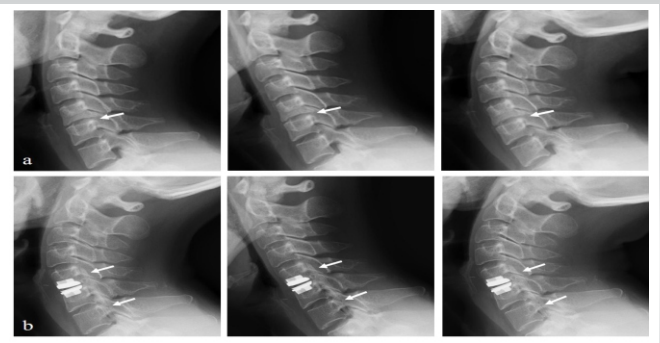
In terms of segmental motion at C5-6, preoperative radiographs showed little segmental motion (white arrows) due to severe spondylosis and loss of disc height more than 50% (Figure 2a). However, due to longitudinal progression of OPLL to C5 upper body and C5-6 disc space and T1 (white arrows), there was no segmental motion at C5-6 with the cervical disc arthroplasty (CDA) at 13 years after CDA (Figures 2b).
